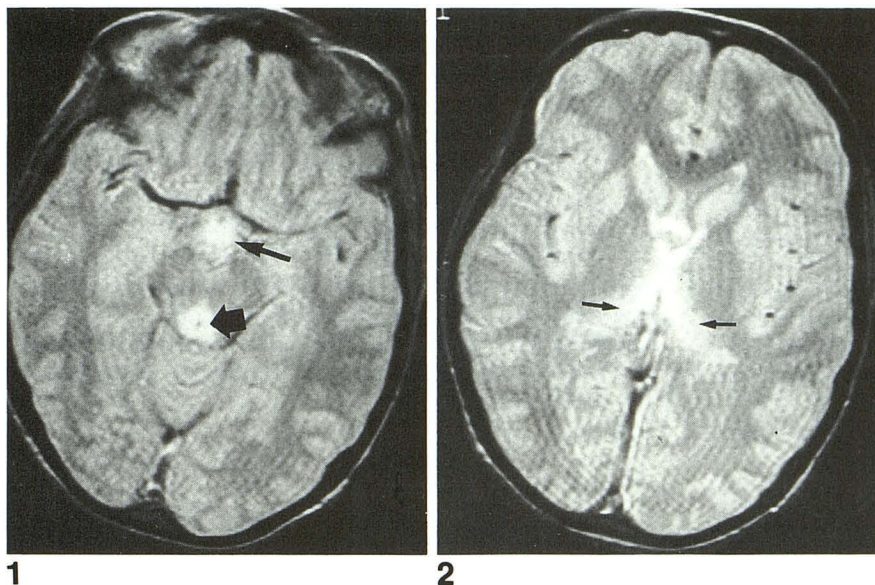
Proton-density MR image (2500/30 [repetition time/echo time]) from April 1991 shows symmetric signal abnormalities in the periaqueductal areas of the midbrain (*wide arrow*) and the hypothalamic/mammillary body region (*thin arrow*). In this figure and those that follow, motion artifacts are present.
